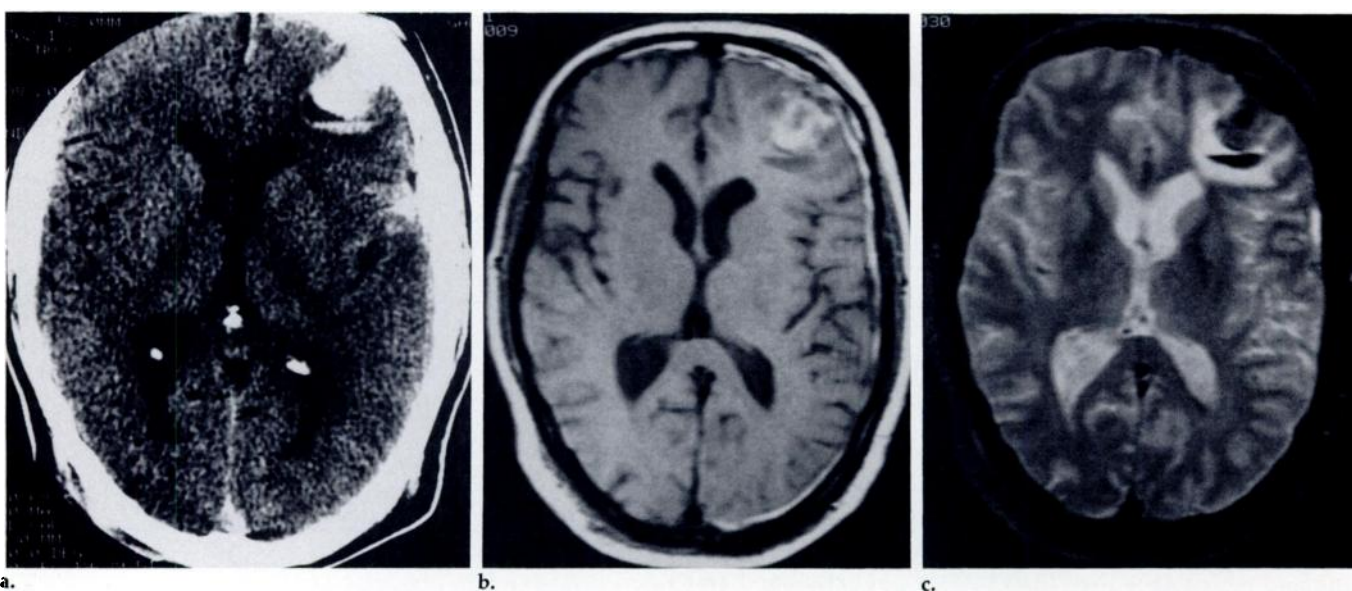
Head trauma in a 47-year-old man. (a) Unenhanced CT scan 2 days after trauma. The left-sided frontal ICH has two parts, one with a fluid-fluid level (layered separation of fluids of different densities). There is also a left temporal contusion. (b) Axial T1-WI 6 days after trauma (TR, 800 msec; TE, 25 msec). In the fluid-fluid level, the supernatant is isointense to white matter, and the dependent portion is slightly hypointense to gray matter. The other part of the ICH shows peripheral hyperintensity and a central isointensity to gray matter. There are small hyperintense SDHs in the left hemispheric and right frontal regions. (c) Axial T2-WI (TR, 2,500 msec; TE, 70 msec). Perihematoma edema is now appreciated as hyperintensity. The dependent hematoma and the center of the nonlayered hematoma are clearly hypointense. The region of hyperintensity on the T1-WI is isointense, and the supernatant is hyperintense.
